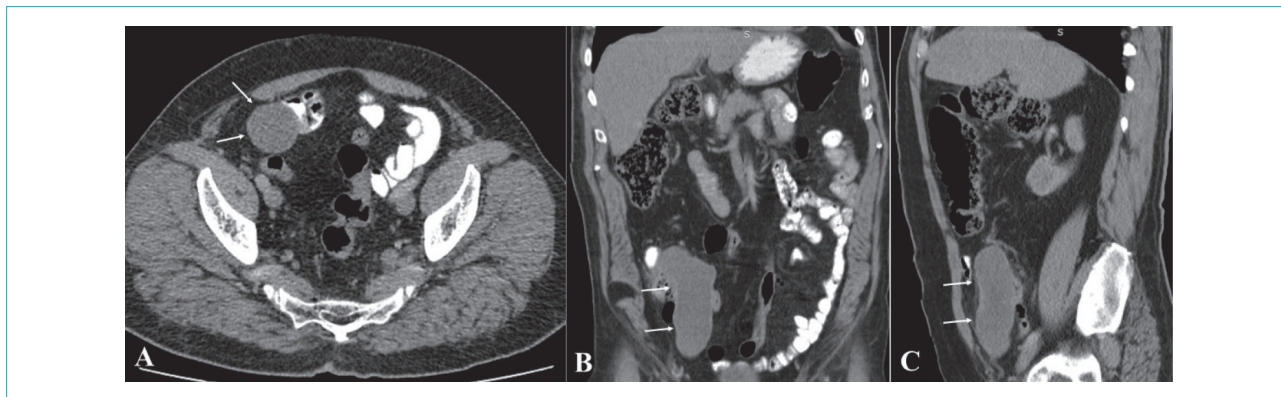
CT images of an AMN (arrows): A – axial view; B – coronal view; C – sagittal view
